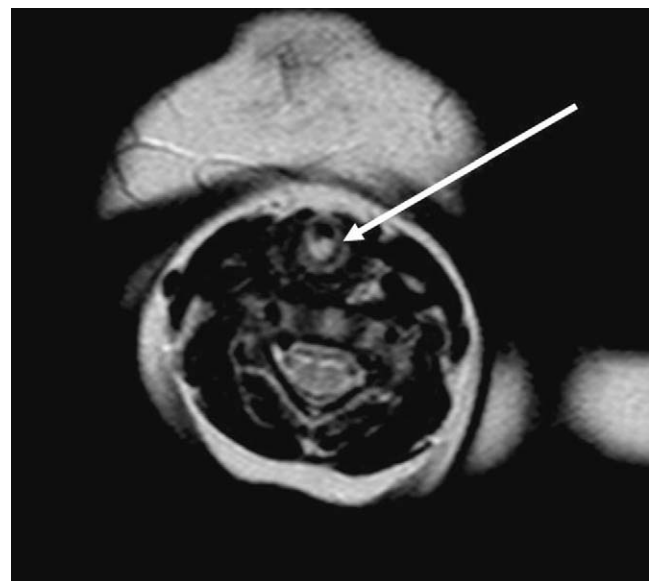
Same patient, cervical MRI, T2-weighted sequence: right posterior tracheal IH with high-intensity signal (arrow).
